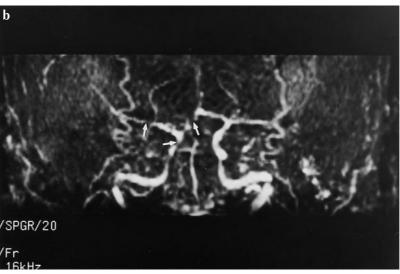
A case of tuberculous meningitis. a MRI coronal view TIWI after intravenous administration of gadolinium-DTPA contrast shows abnormal enhancement in right sylvian fissure (arrow), and basal cistern (arrow head); b Three-dimensional time-of-flight MRI angiogram of the same case shows multiple narrowings of the vessels (arrows) consistent with arteritis.
